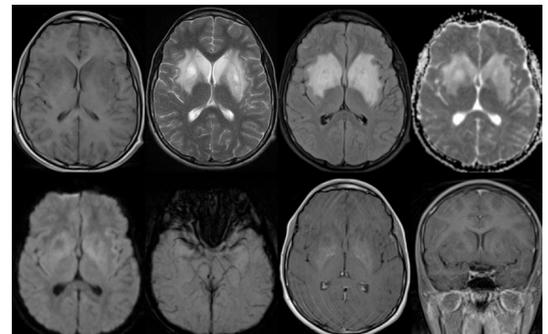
Bilateral symmetrical T2/FLAIR hyperintensities with swelling of bilateral basal ganglia, internal and external capsule, claustrum and extreme capsule with sparing of the insula; no diffusion restriction with minimal contrast enhancement.
